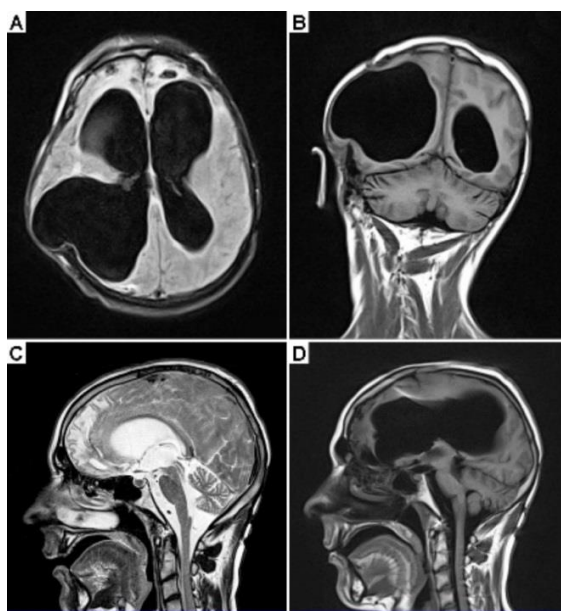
MRI of a 23-year-old male patient with a very severe traumatic brain injury. The pictures were taken one year after the car accident. Since a metal shard went into the brain during the accident, some brain tissue had to be removed. A shunt was installed to regulate brain pressure. Because of the loss of nervous tissue, the ventricles became enlarged; they look like in cases of hydrocephalus. Many parts of the brain were damaged during the accident, including both frontal lobes (A, C). The artifact from the shunt can be seen in ‘C’.
